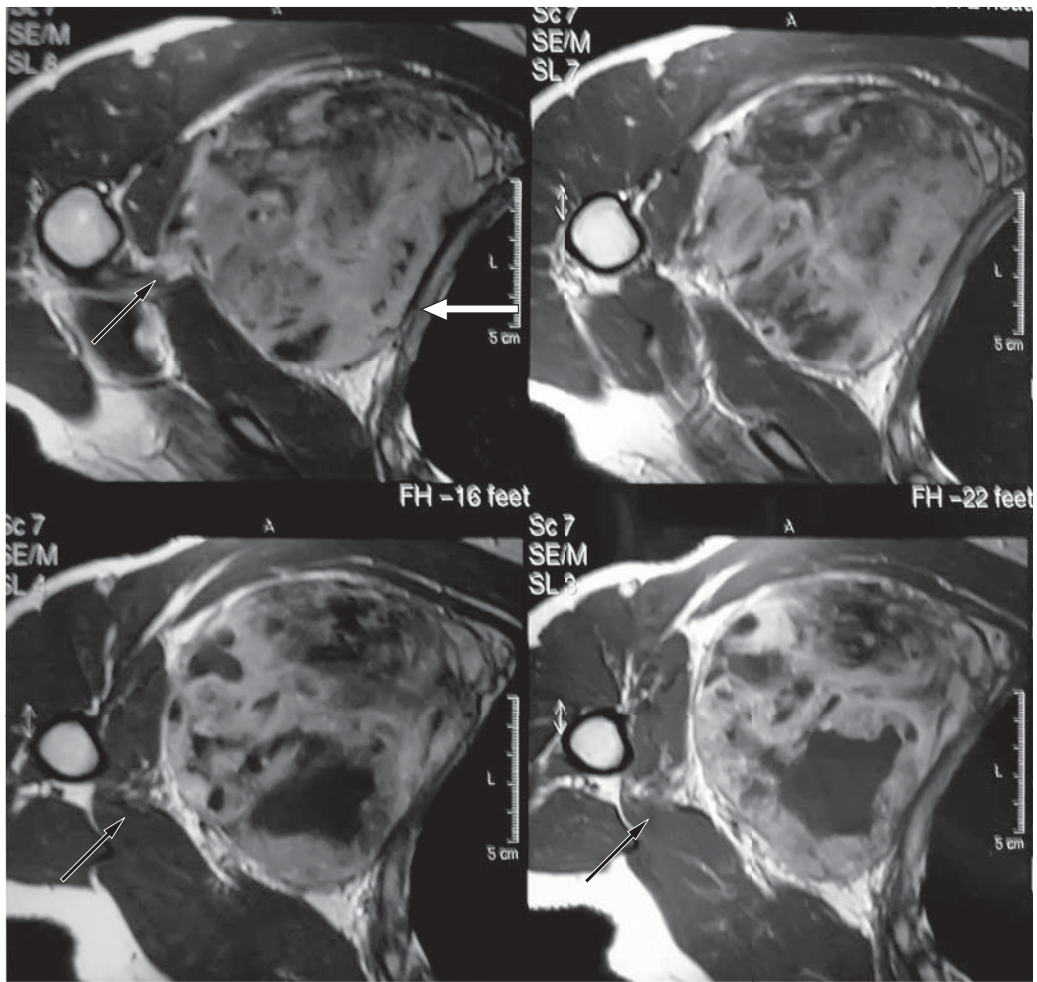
Axial MR images; T1 sequence without fat saturation after intravenous gadolinium. Heterogeneous tumor in the axilla abutting the chest wall (white arrow) and the neurovascular bundle (black arrows).
